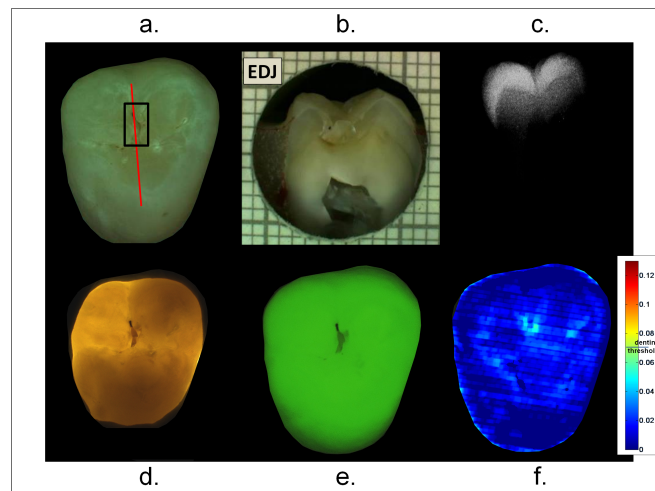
Tooth with enamel demineralisation. All the techniques scored this tooth as with a lesion in the enamel, in particular the ICDAS and FOTI scores were both 1, QLF scored it with a lesion at the E1, Radiography scored it as a 2 and NIR as with a lesion at the E2.
